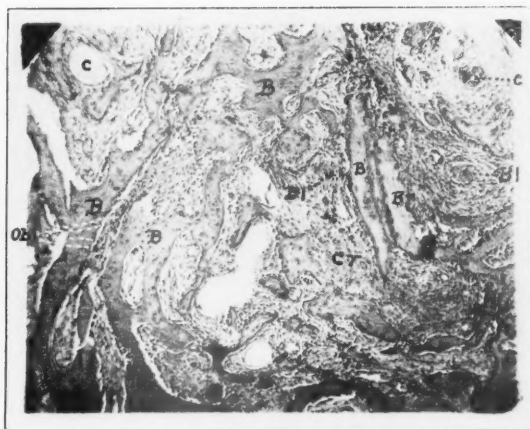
Sphenoid sinus wall ($\times 100$). Heteroplastic bone formation in young connective tissue. B—Bone. CT—Young connective tissue cells and fibrin. Ob—Osteoblasts. C—Blood capillary. BI—Bone islands.
